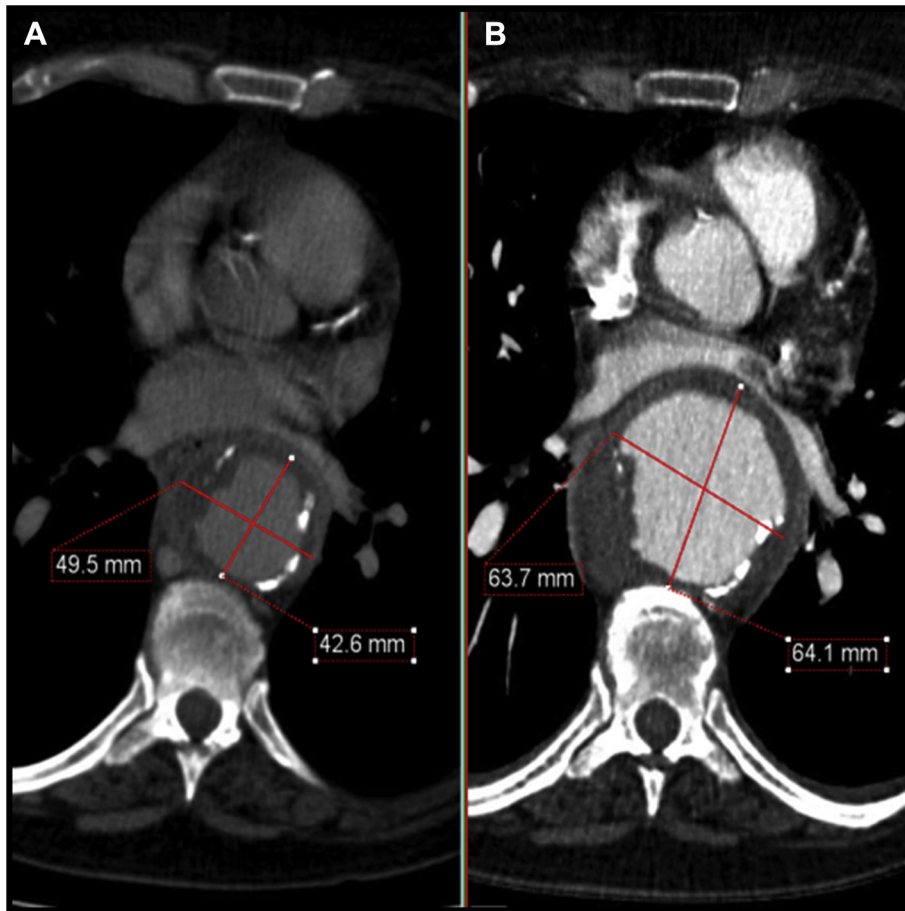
Cross-sectional images: (A) Initial computed tomography angiography (CTA) demonstrates the thoracic component of the mycotic aortic aneurysms (MAAs). B, The CTA 1 week later showed rapid expansion.
